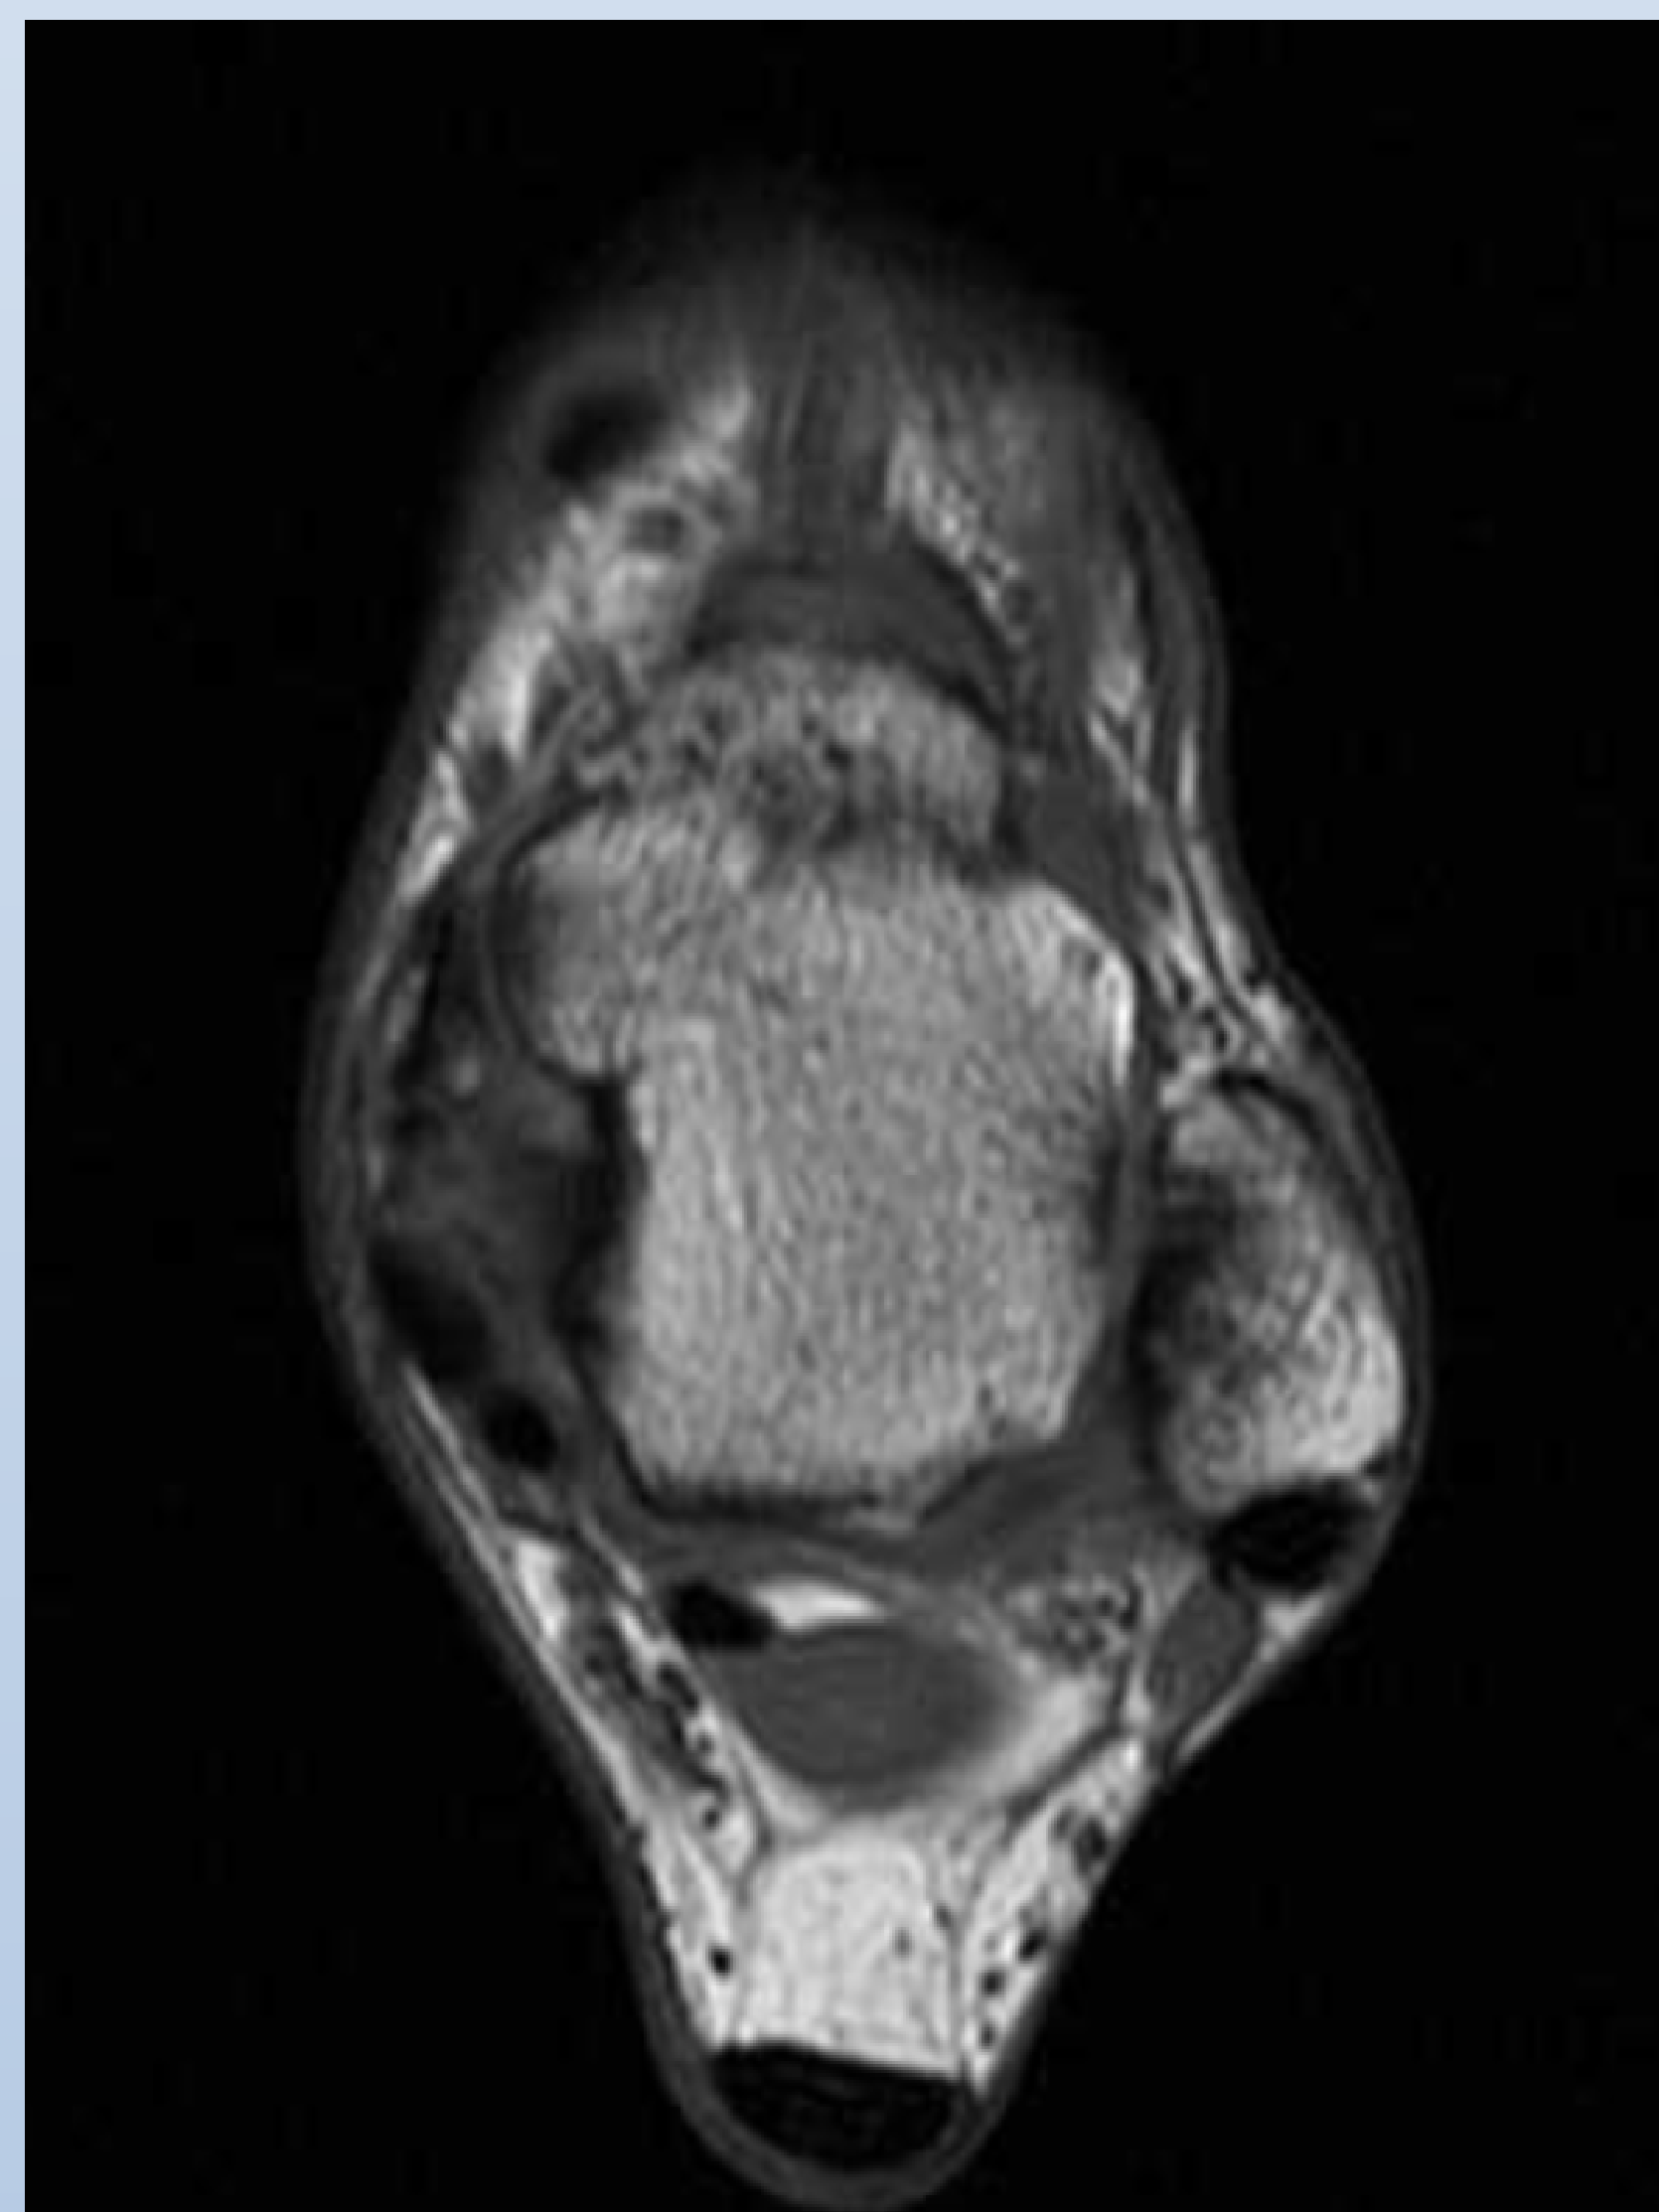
Axial T1 MRI Left Ankle
